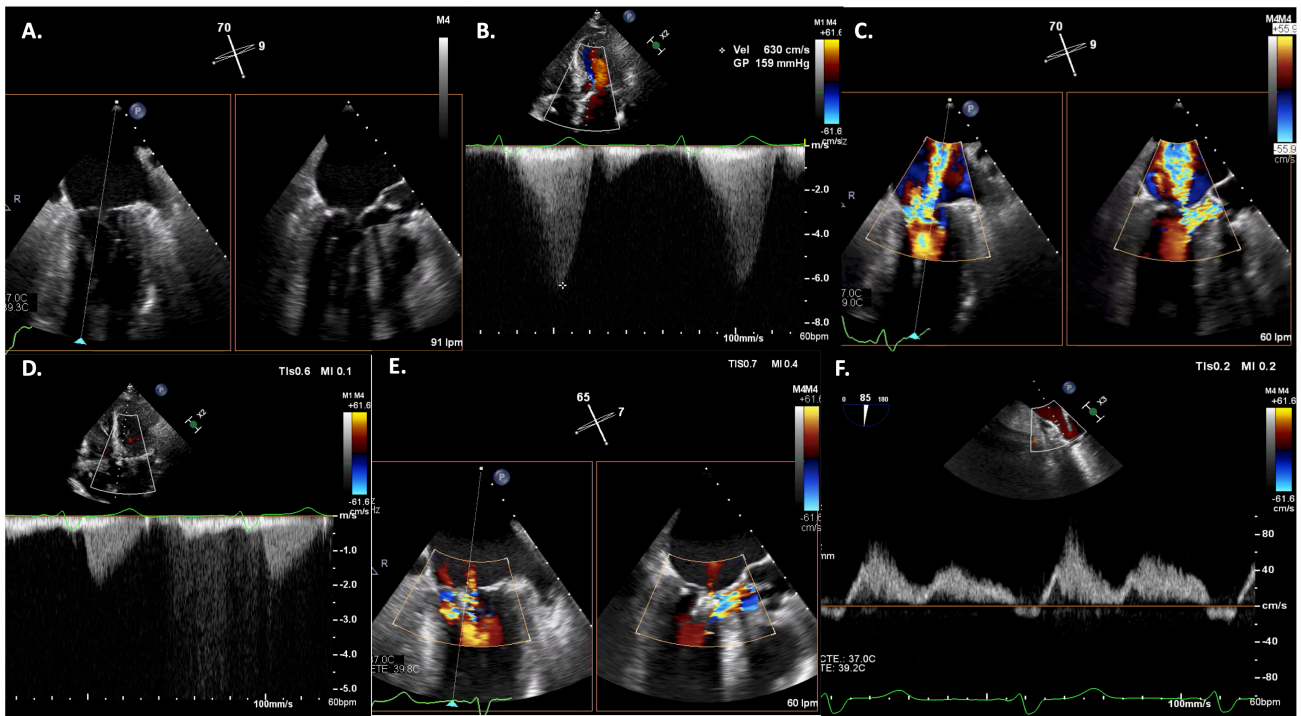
Mitral transcatheter edge-to-edge repair (M-TEER) in a patient with systolic anterior motion (SAM)-associated mitral regurgitation (MR). Transoesophageal echocardiogram showing baseline SAM of the anterior mitral leaflet (AML) (A), leading to severe left ventricular outflow tract (LVOT) obstruction (B) and severe MR (C). After M-TEER with 2 Mitraclip™ implantation, resolution of LVOT obstruction (D), with residual mild MR (E,F).
